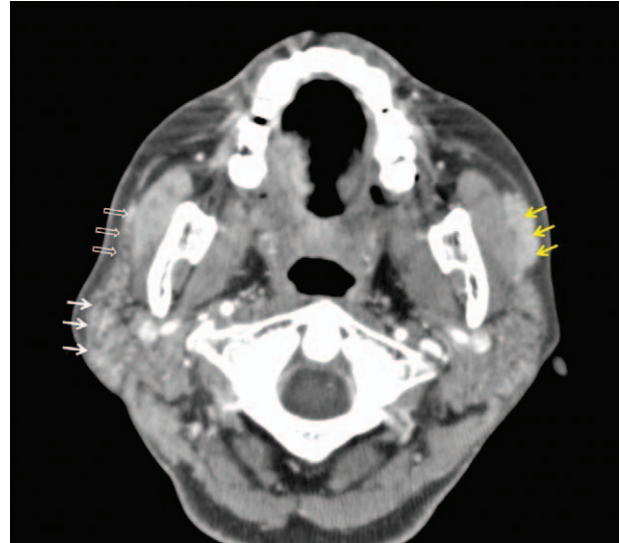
Enhanced computed tomography revealed a homogeneously enhancing mass measuring 2.5×0.8 cm in the left accessory parotid gland (yellow arrows). The right parotid gland (white arrows) and the right accessory parotid gland (empty arrows) were intact.
